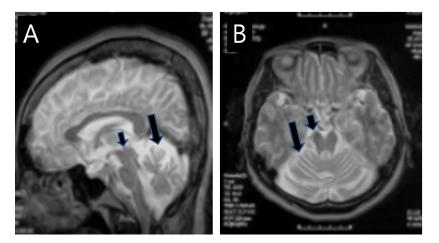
Brain magnetic resonance imaging of Patient 1
